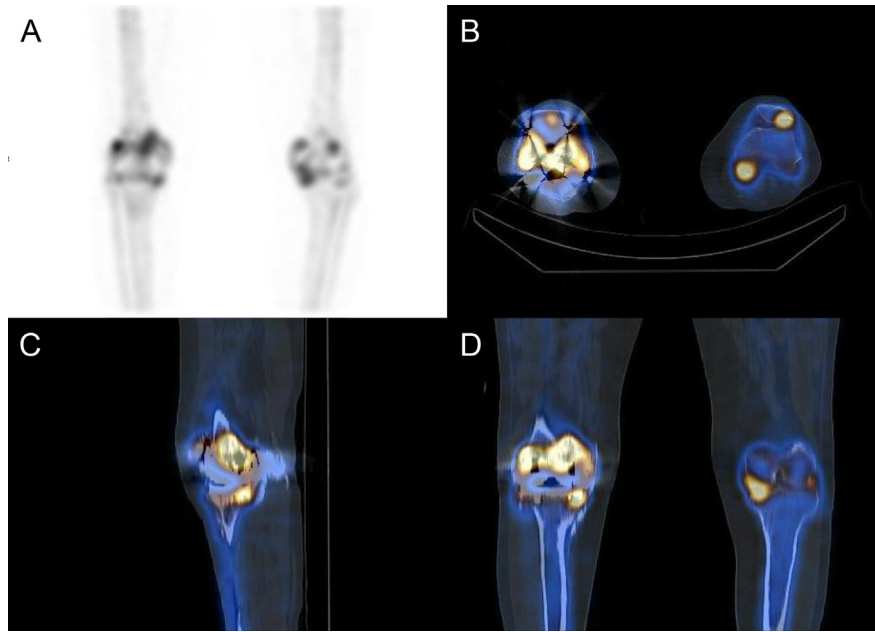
Bone scintigraphy and single-photon emission computerized tomography/computerized tomography A) coronal maximum intensity projection image; B) transaxial image; C) sagittal image; D) coronal image] of a failed oxidized zirconium total knee arthroplasty showed focally methylene diphosphonate uptake in the right femoral condyle, which was possibly due to osteolysis.
